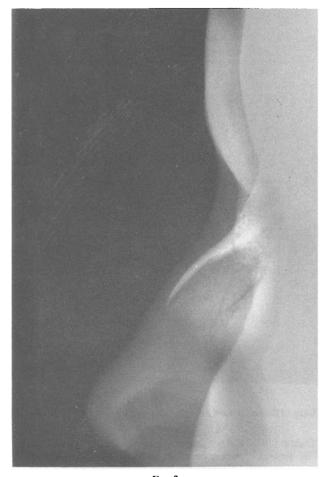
Lateral radiograph of the nasal bone showing the fine reticular osteolytic lesion.
